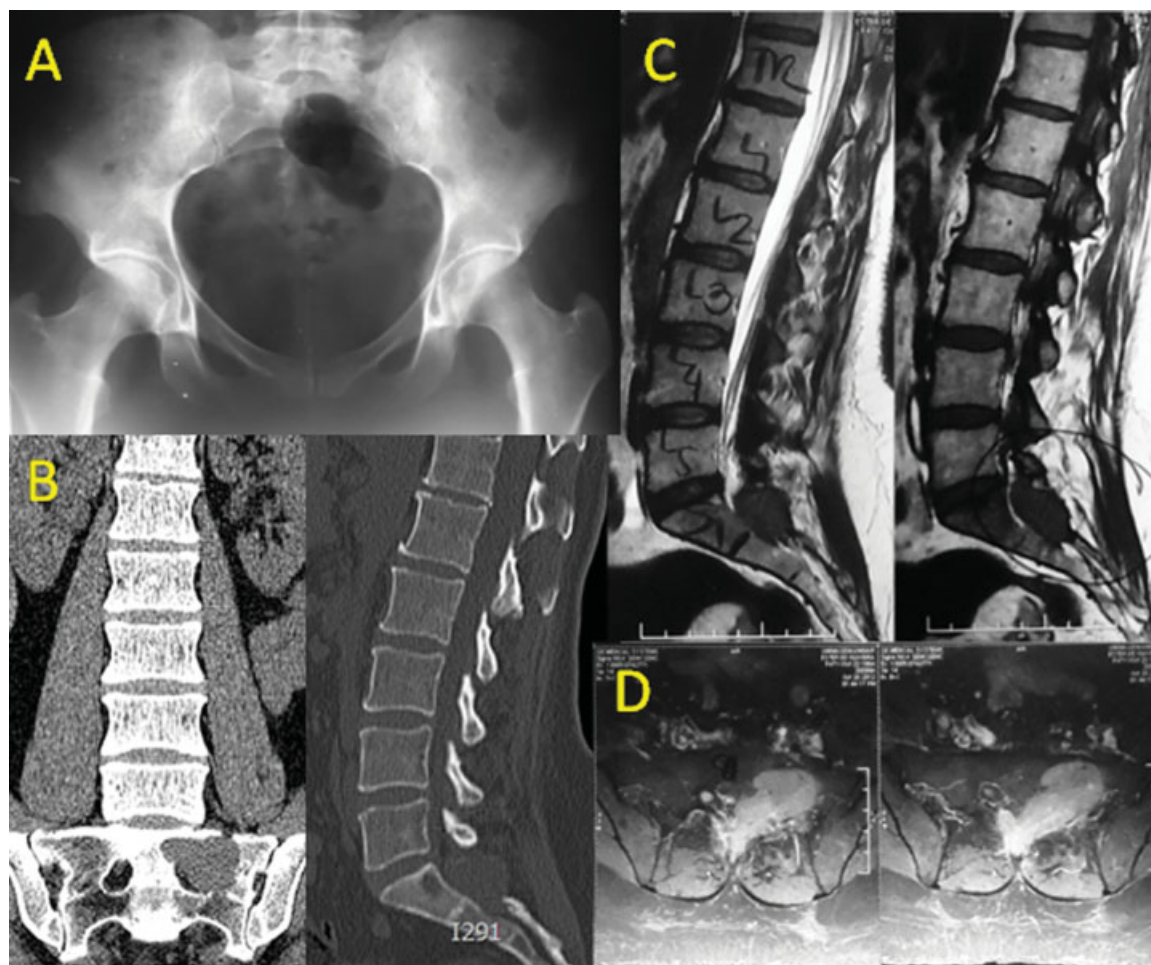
Radiologic evaluation. (A) A pelvic radiography with interference of gas in the colon. (B) Lumbar and sacral tomography revealing an osteolytic lesion in left S1 lamina, invading vertebral canal. (C) Sagittal magnetic resonance imaging displaying a solitary hypointense T1 and T2 lesion on the left lamina of S1. (D) Axial magnetic resonance imaging on the left lamina of S1 homogeneously enhancing after endovenous gadolinium injection.
